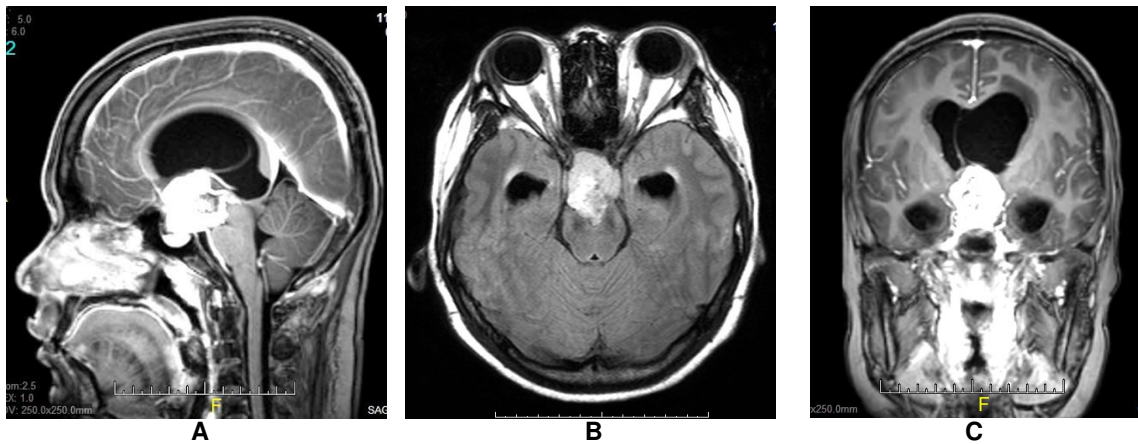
MRI showing heterogeneous enhanced lesion at the third ventricle extending intosuprasellar region and impinging the right optic nerve with accompanied hydrocephalus
